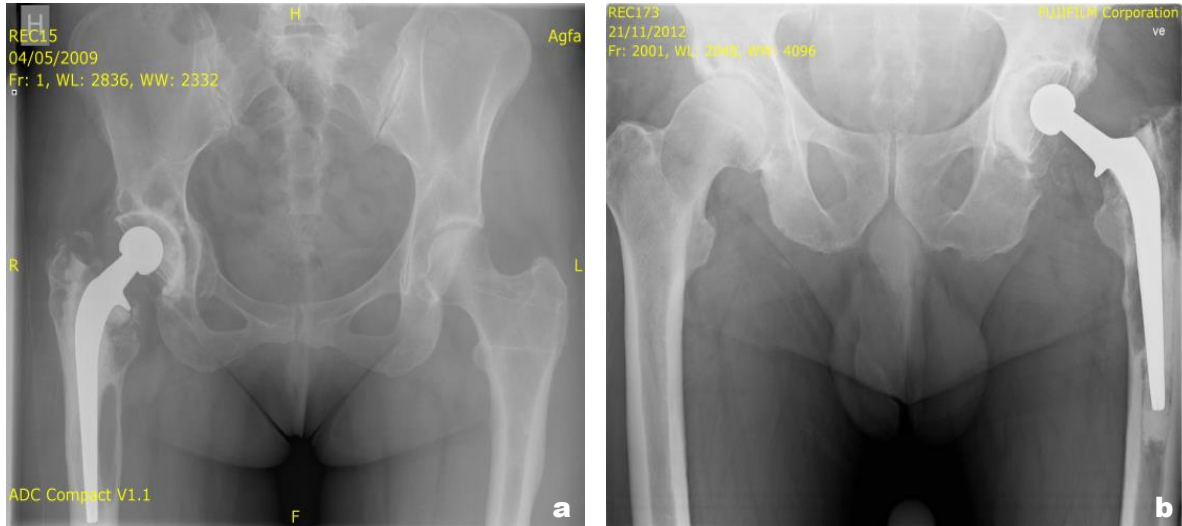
Examples of X-rays presented massive osteolysis around the stem (a. Rec15; b. Rec173)
